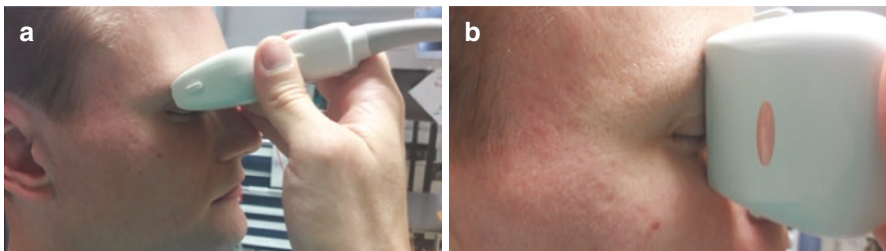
Position of the probe for ultrasonographic measurements of ONSD in transverse view (a) and parasagittal view (b)
